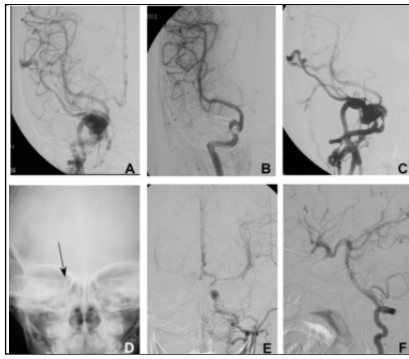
A 5-year-old girl (patient 6) had a traumatic CCF on the right side. Injection through the right ICA revealed a direct CCF with venous drainage primarily through the ophthalmic vein. B. The detachment of a detachable balloon within the right cavernous sinus led to the complete obliteration of the fistula with concurrent compromise of the ICA. The right anterior cerebral artery was primarily supplied by the contralateral collateral circulation through the anterior communicating artery. C. Half a month later, the CCF was recurrent due to the premature rupture of the balloon within the cavernous sinus. D. Plain cranial x-ray film demonstrated the small mark on the deflated balloon (arrow). E&F. The right ICA was successfully sacrificed using two balloons with one detached within the right cavernous sinus and the other in the right ICA proximal to the fistula. Injection through the left ICA showed that the right anterior cerebral artery was supplied by the left ICA (E). Injection through the right vertebral artery demonstrated that the right middle cerebral artery was supplied by the right vertebral artery through the posterior communicating artery (F).
